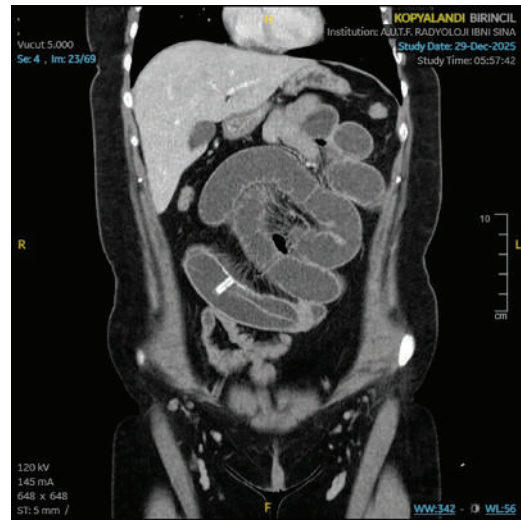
CT Imaging findings consistent with mechanical obstruction at the level of the small intestine.
